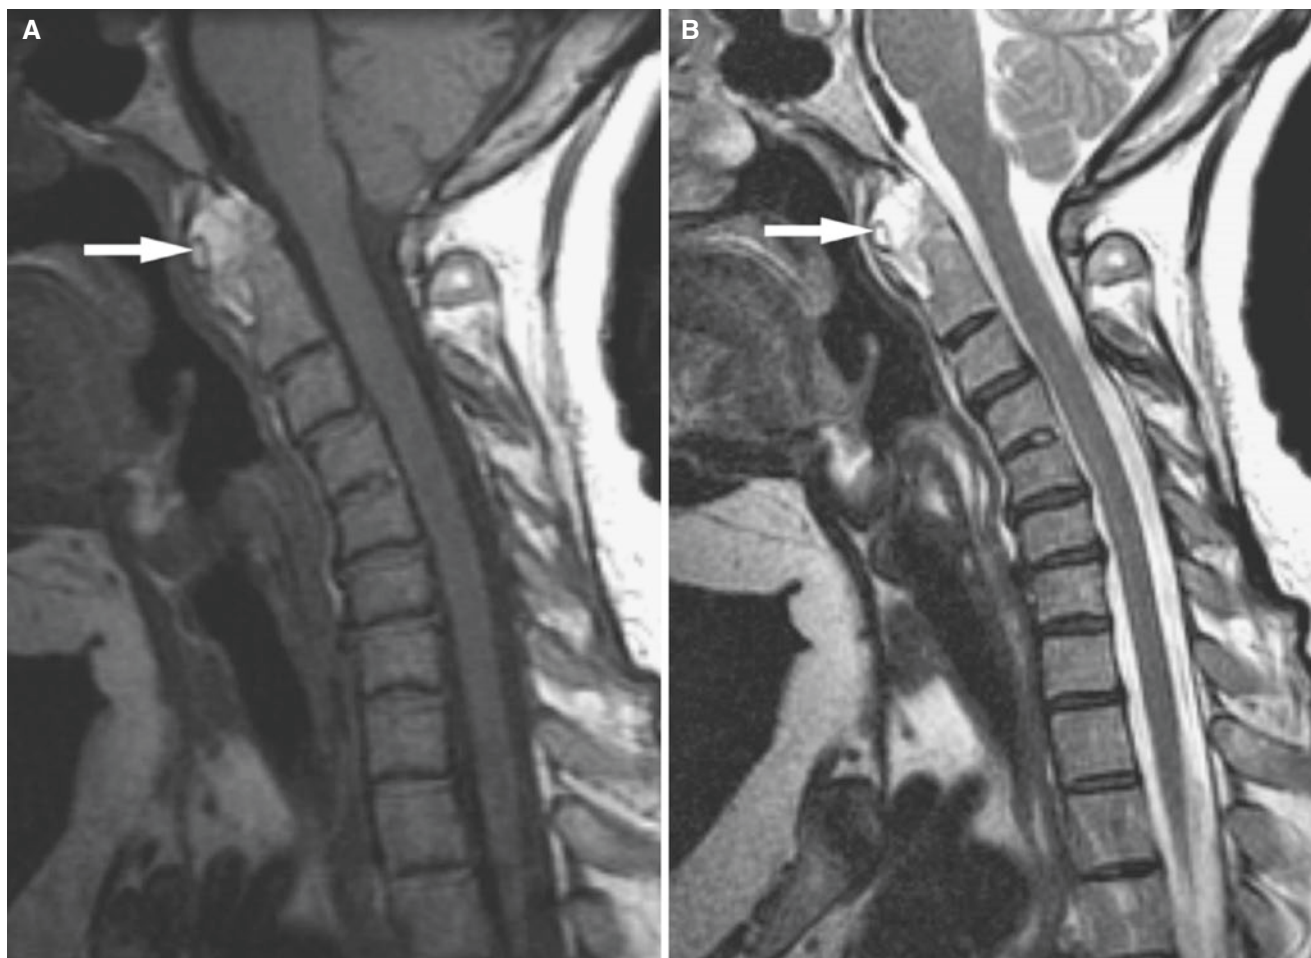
Rheumatoid pannus at craniocervical junction; 46-year-old female with long history of rheumatoid arthritis, now with cervical spine pain. (A) Sagittal T1-weighted MRI shows hyperintense mass anterior to eroded dens (*arrow*). (B) Sagittal T2-weighted MRI shows
